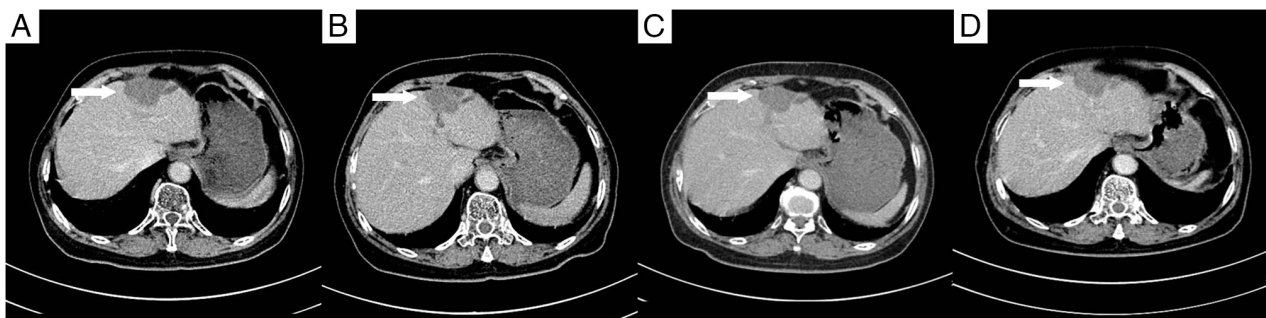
Enhanced computed tomography scan of the lesion in the left lobe of the liver post-HIFU. (A) The lesion measured 38x33 mm at 3 months post-HIFU (arrow). (B) The lesion measured 37x33 mm at 6 months post-HIFU (arrow). (C) The lesion measured 35x32 mm at 18 months post-HIFU (arrow). (D) The lesion measured 33x30 mm at 2 years post-HIFU (arrow). HIFU, high-intensity focused ultrasound.
